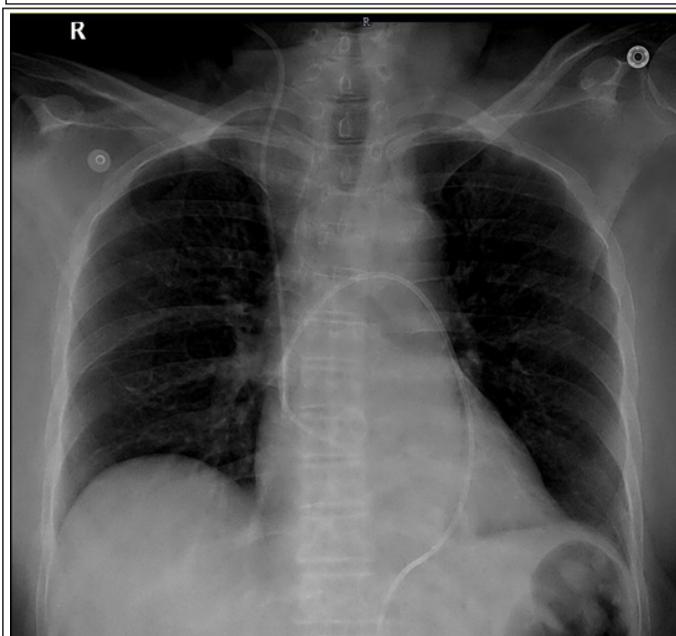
Chest X-ray post-pericardiocentesis with pigtail catheter in-situ showing reduction in width of cardiac silhouette.
